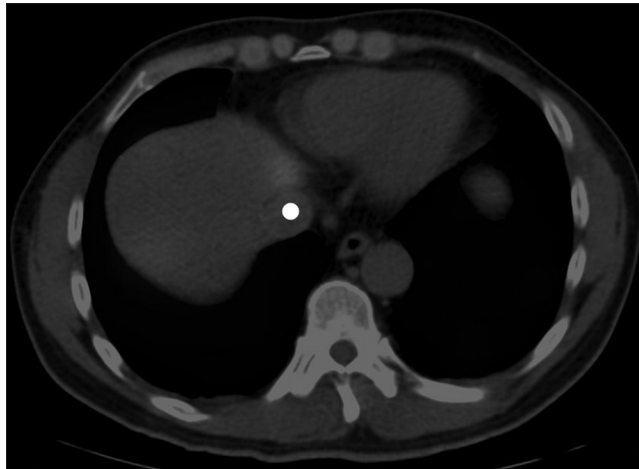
SPECT/CT immediately after administration of Tc-99m MAA showing no uptake by the IVC tumor thrombus (white dot)
